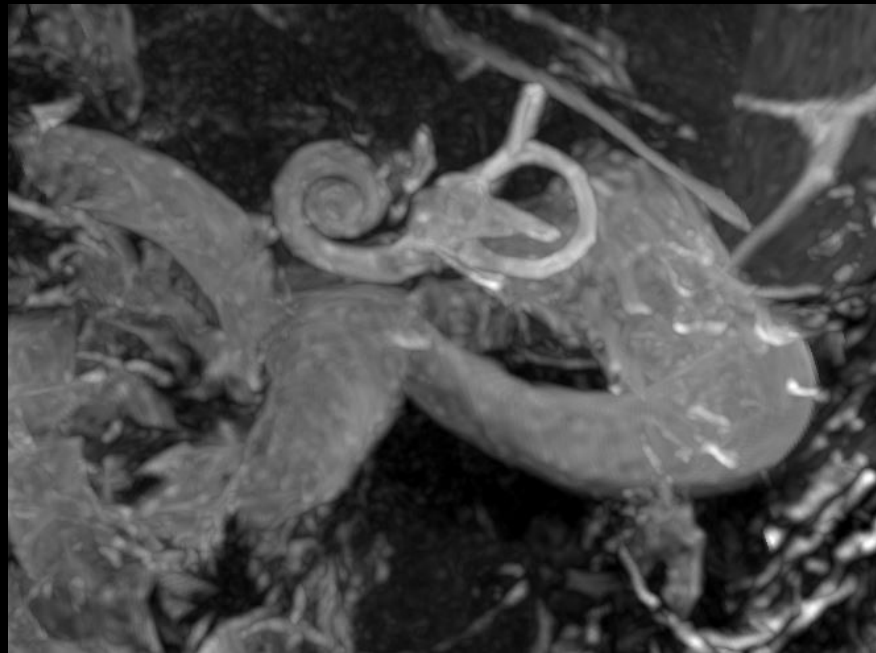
IMAGERIE DU MAI ET DU LABYRINTHE EN IRM 3T HR EVOLUTIONS ET PERSPECTIVES
